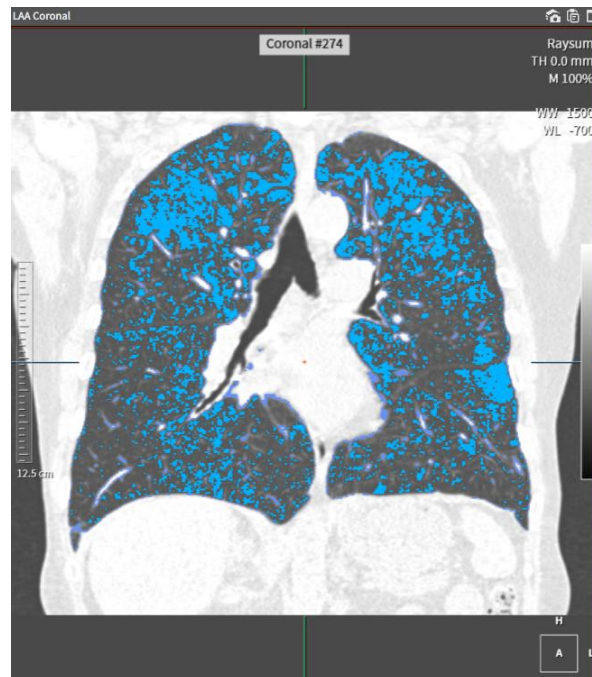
An example of a CT scan with LAA coloured in blue in a coronal view, quantified by the Aview system
